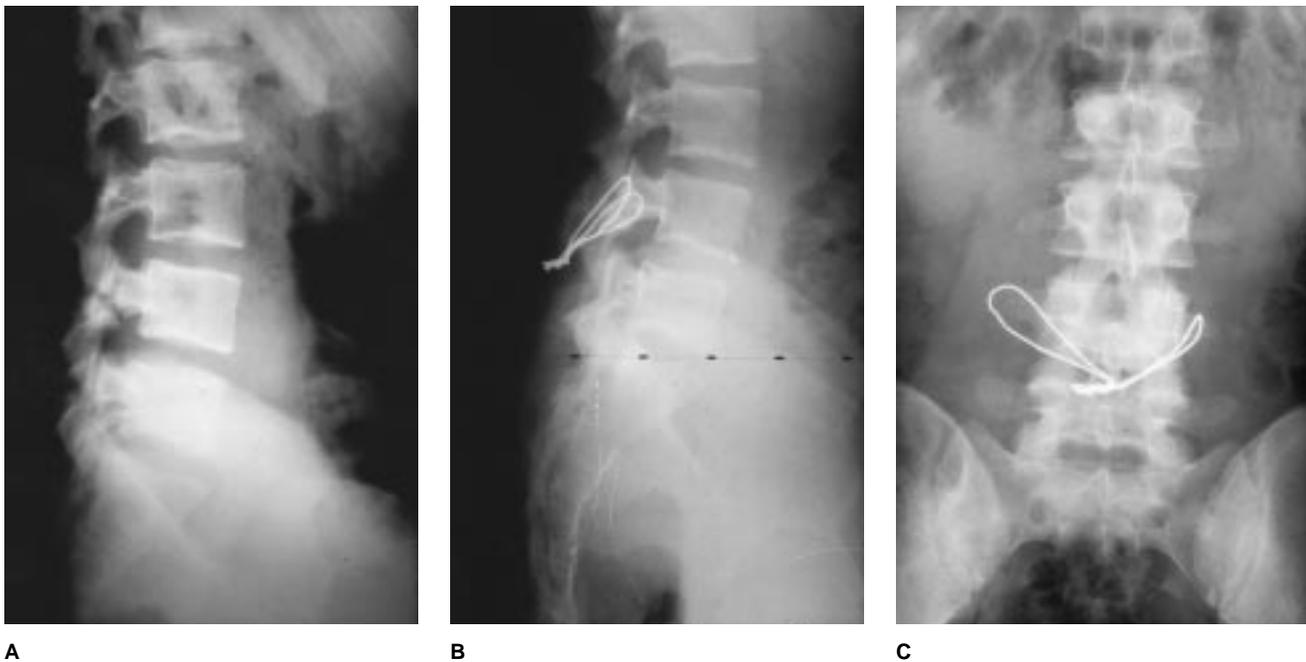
A, Preoperative lateral radiograph of patient with bilateral spondylolysis at L4. Defect measures 3 mm. B, Postoperative lateral radiograph after internal fixation of bilateral defect and bone grafting. C, Postoperative anteroposterior radiograph.
